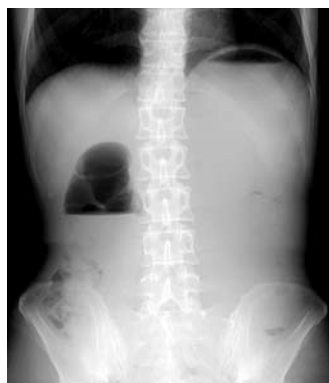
Abdominal X-ray showing a distended stomach with air fluid level in the stomach and duodenal bulb. The "Double bubble sign" was consistent with high small bowel obstruction.
